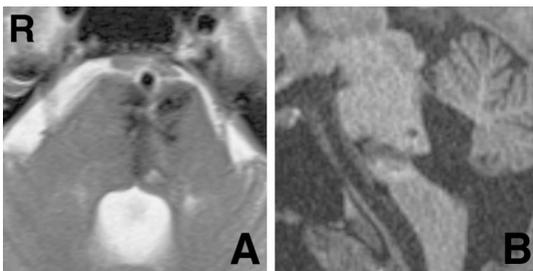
A: Axial T₂-weighted magnetic resonance (MR) image showing complete resection of the ventral pontine cavernoma. B: Sagittal T₁-weighted MR image using magnetization-prepared rapid acquisition gradient echo revealing the enlarged entrance of the route on the floor of the fourth ventricle.
